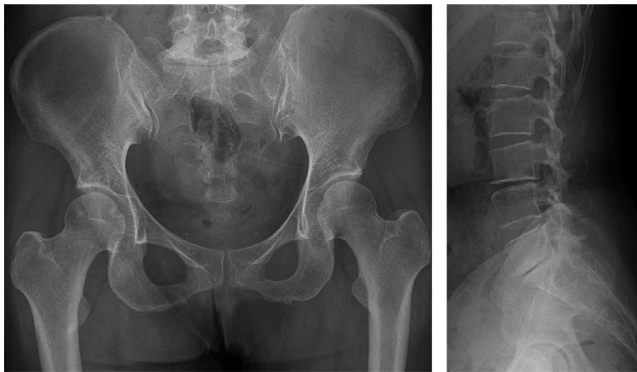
Pelvis anteroposterior and lumbar lateral radiographs of a 48-y-old woman
